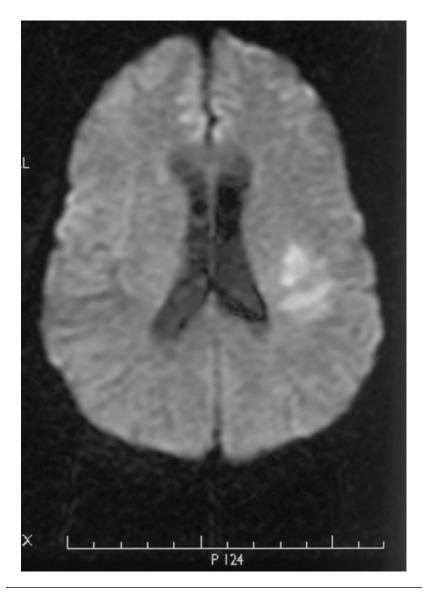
Acute ischemic lesion. Diffusion-weighted MRI shows hyperacute left subcortical bright ischemic lesion.
